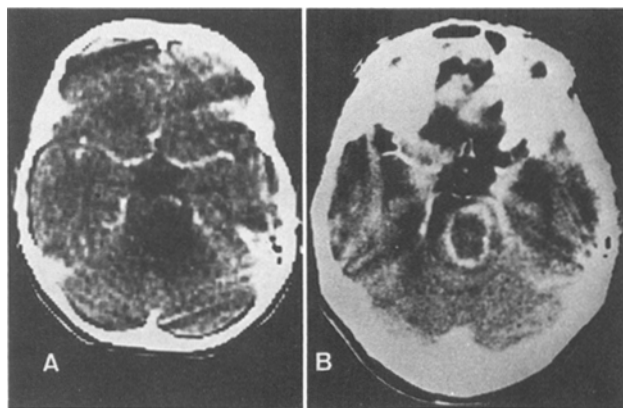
Computed tomography after contrast enhancement of two typical cases. A) Nonenhancing brainstem glioma, B) ring-enhancing brainstem glioma
